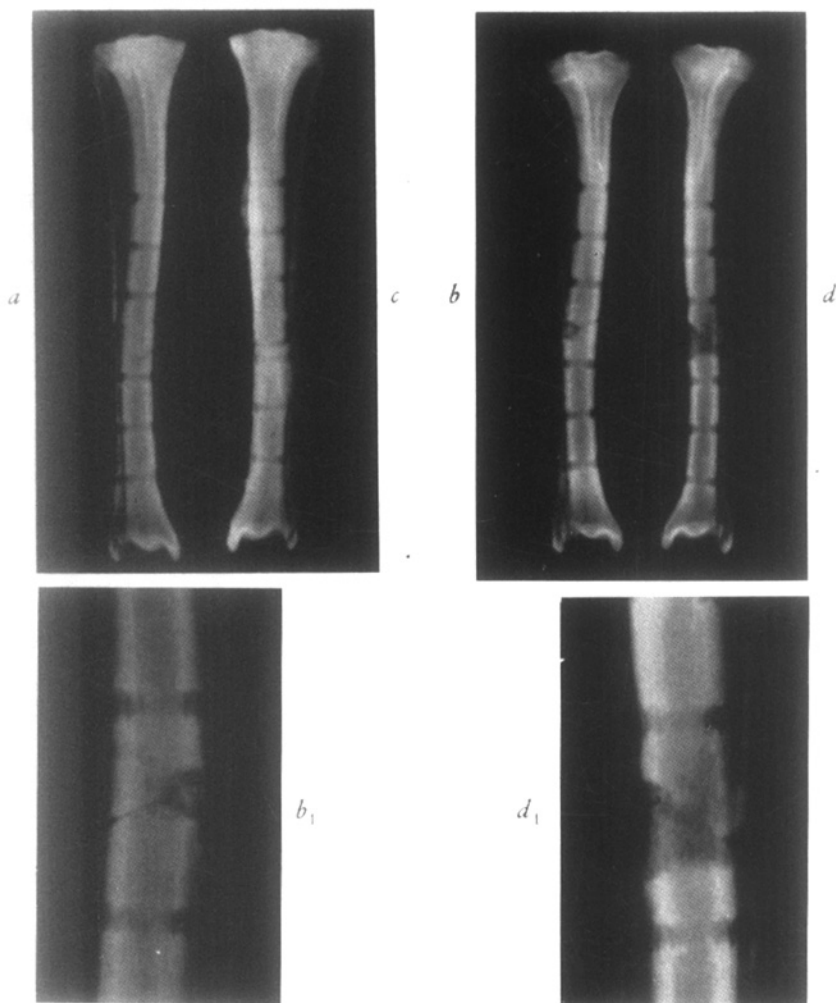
Roentgenograms showing the position of the intermediate fragment in the tibial diaphysis and the healing of the osteotomies: *a* - After an observation time of 4 weeks: The osteotomy gaps are still well visible but endosteal callus is present, especially in level with the lower gap. *b* - After an observation time of 6 weeks: The lower osteotomy gap is almost completely filled, and the upper gap is partially open. The fibular part of the intermediate fragment is undergoing pronounced reconstruction. *c* - After an observation time of 8 weeks: The lower osteotomy gap shows a tendency to delayed union, and the upper gap is almost filled. The structure and mineral content of the intermediate fragment are essentially retained. *d* - After an observation time of 10 weeks: Both osteotomy gaps healed. Considerable reconstruction of the intermediate fragment and especially the marginal zone of the upper main fragment. *b₁* - enlargement of the 6 week preparation. *d₁* - enlargement of the 10 week preparation.
